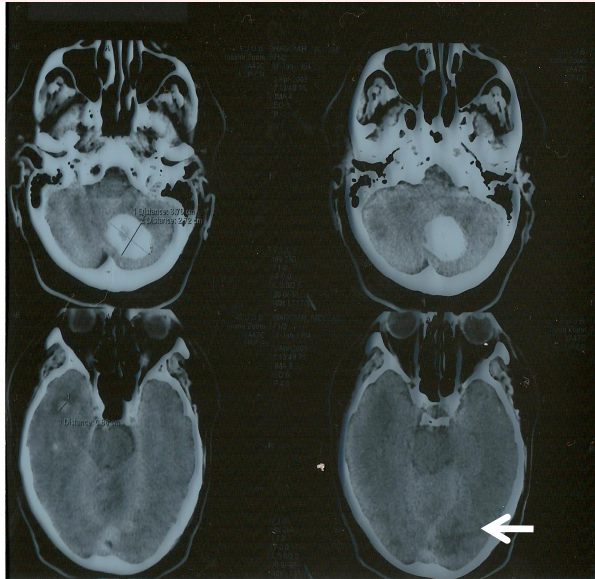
The brain CT scan without contrast performed in the admission day revealed a left cerebellar hemorrhage with surrounding edema and compressive effect in the fourth ventricle but no appreciable underlying mass. A small hemorrhage of 9 mm with perilesional edema localized in the right temporal lobe was also identified. A left occipital hypodense brain area with digitiform borders was found as well (white arrow).
